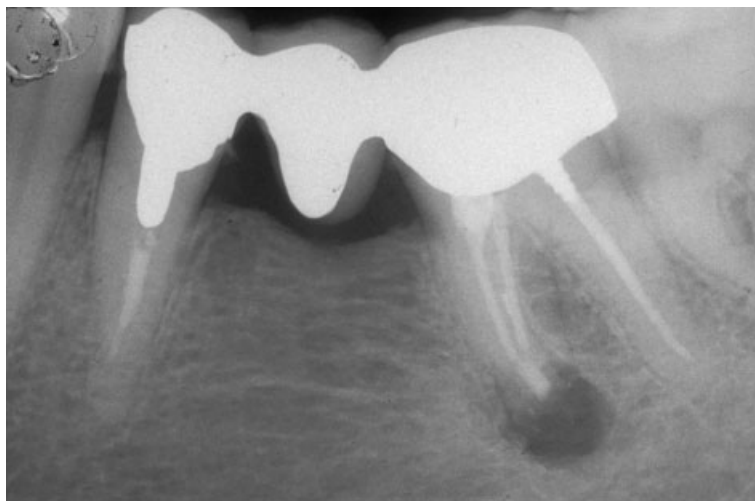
The radiographic appearance just after surgery.
